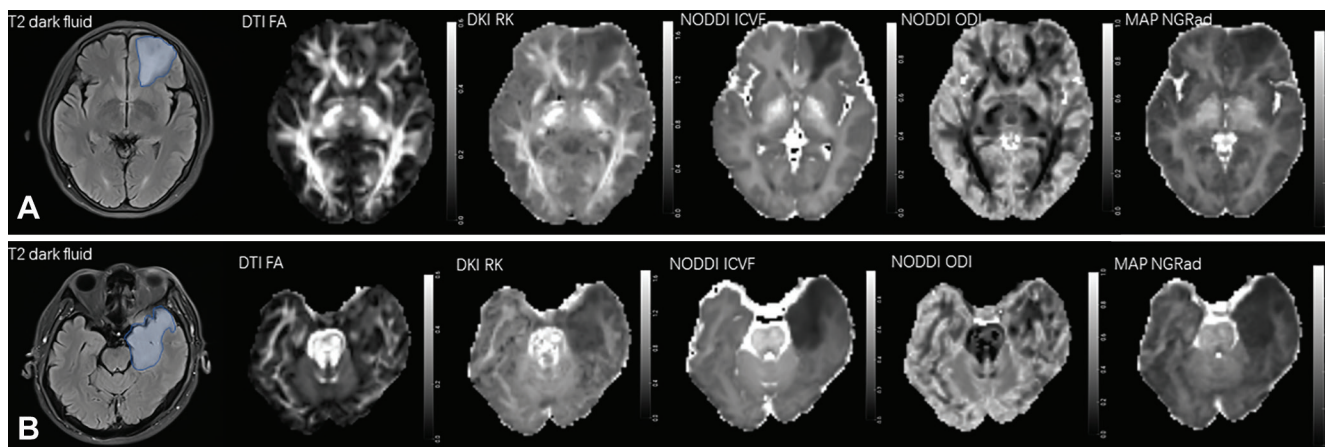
The blue lines on the T2-weighted dark fluid images show the lesions included in the volume of interest. (A) Images in a 52-year-old woman with World Health Organization (WHO) grade II oligodendroglioma with isocitrate dehydrogenase (*IDH*) mutation type and *1p/19q* codeletion. (B) Images in a 52-year-old man with WHO grade II astrocytoma with *IDH* wild-type and *1p/19q* non-codeletion. DKI = diffusion-kurtosis imaging, DTI = diffusion-tensor imaging, FA = fractional anisotropy, ICVF = intracellular volume fraction, MAP = mean apparent propagator, NGRad = radial non-Gaussianity, NODDI = neurite orientation dispersion and density imaging, ODI = orientation dispersion index, RK = radial kurtosis.
